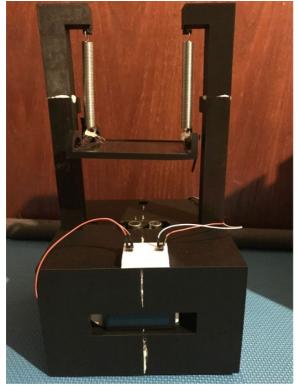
A suspended design using an ultrasonic distance sensor
